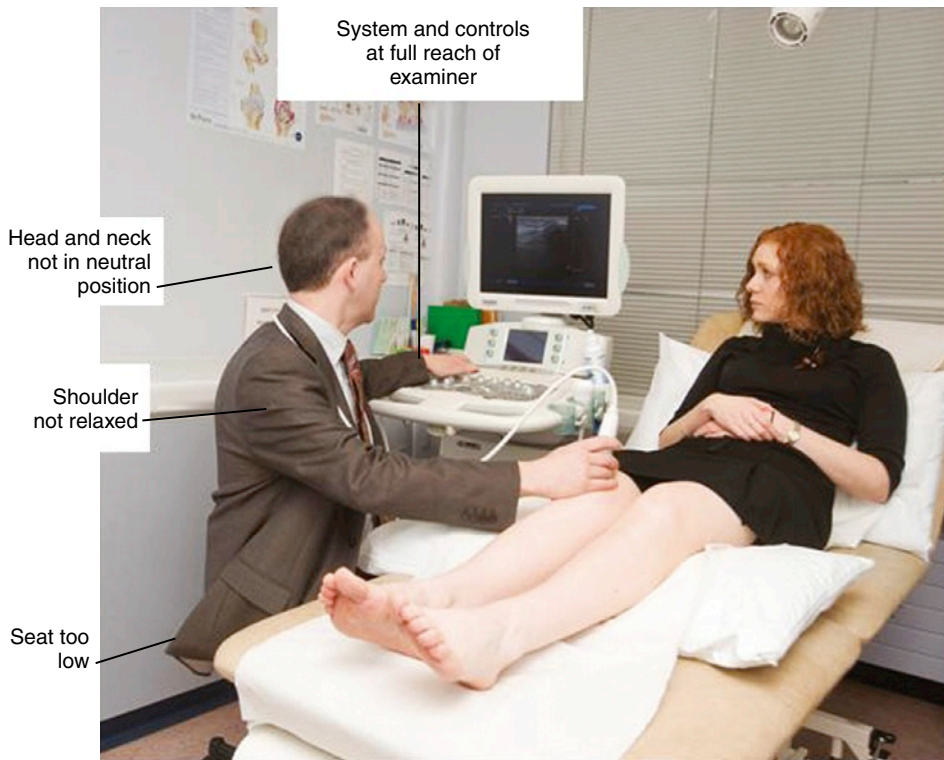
By correcting the poor ergonomic design of this workstation, the operator can reduce the risk of neck, shoulder, and back pain and enable faster ultrasound evaluation.
